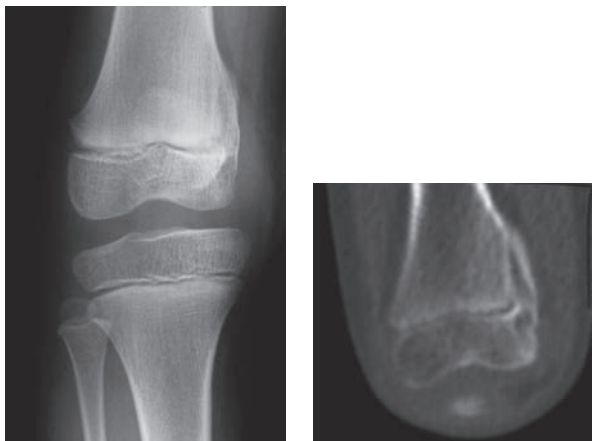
Sequelae of a Peterson type VI physeal injury. A: Anteroposterior radiograph of distal femur of a young girl who suffered a Peterson type VI injury. This particular injury was the result of direct abrasion of the distal femur when the unrestrained child was ejected from a car. B: CT scan 1 year after injury demonstrates the development of a peripheral physeal arrest with valgus deformity.
